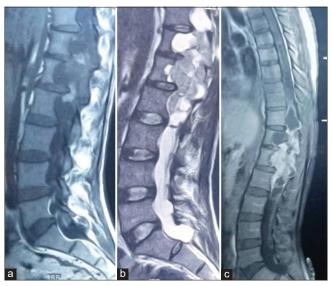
Sagittal T1 (a), T2 (b) and T1+C (c) weighted magnetic resonance images showing mixed intensity, inhomogenously contrast enhancing tumour at T11-L2, with associated syringomyelia and posterior scalloping of T12 and L1.
